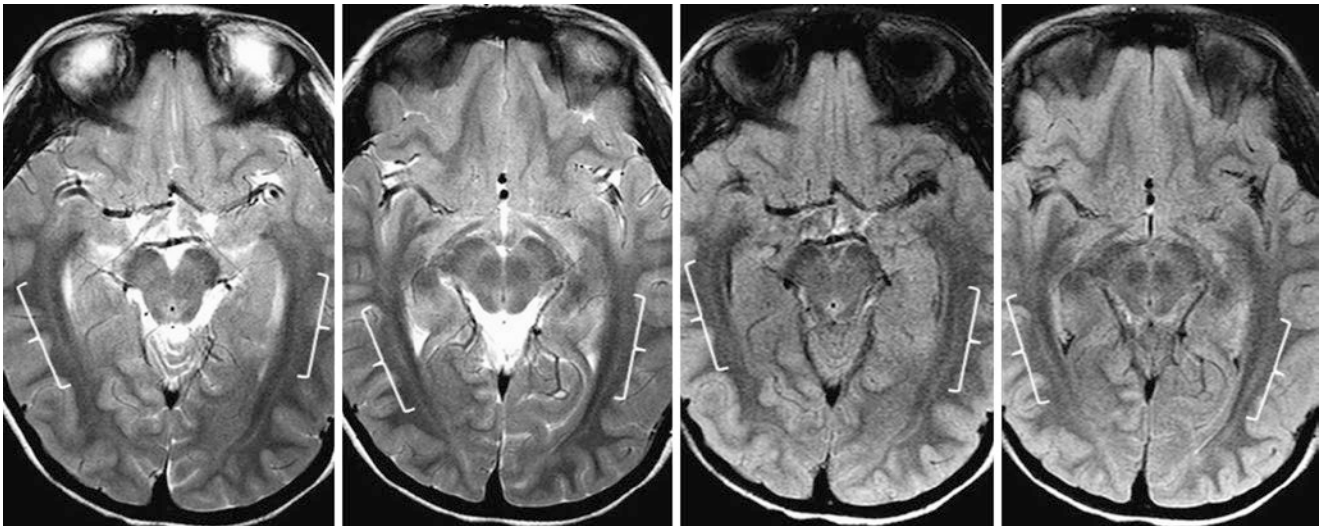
A 6.5-year-old with developmental delay had a normal 3T MRI with SE T2WIs (*left images*) and 2D FLAIR (*right images*). Note terminal zones within the optic radiations (*brackets*), which are contiguous with quite subtle PTWM terminal zones (*not shown*).
